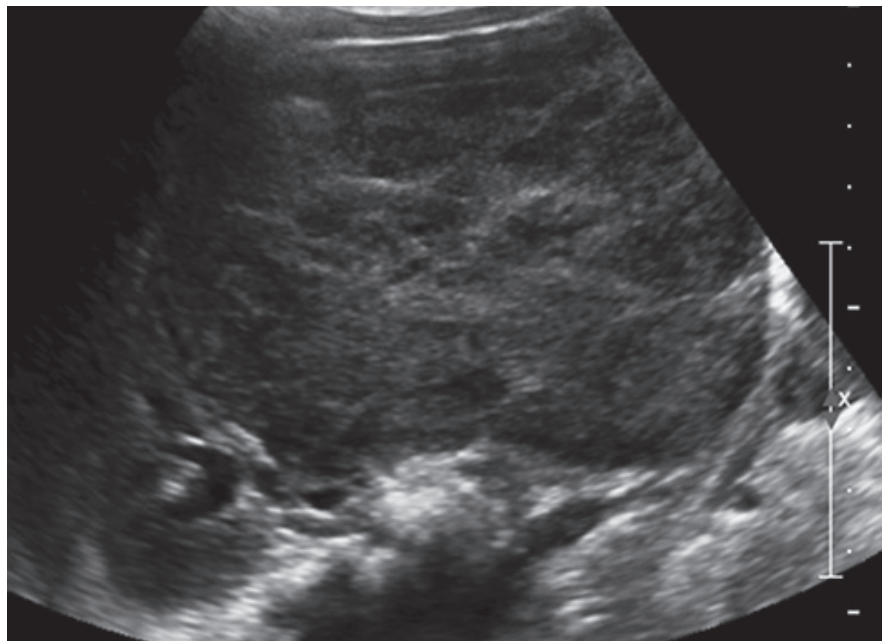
Sagittal ultrasound image of the right kidney demonstrates a heterogeneous mass in the mid and lower pole, with sparing of the upper-pole renal parenchyma.
